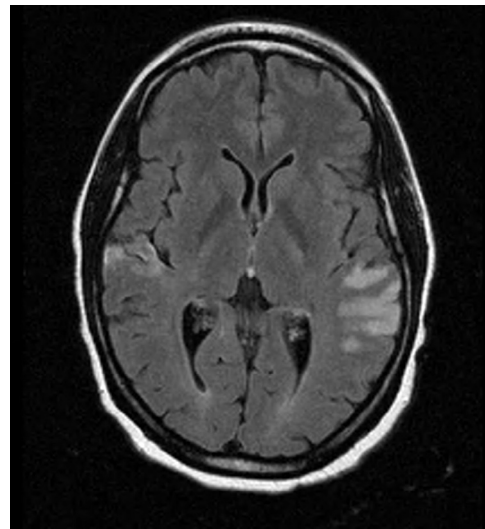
Control brain magnetic resonance imaging FLAIR-weighted sequence performed the following day showing appearance of an increased signal in the territory of the left middle cerebral artery. Abbreviation: FLAIR, fluid attenuated inversion recovery.
